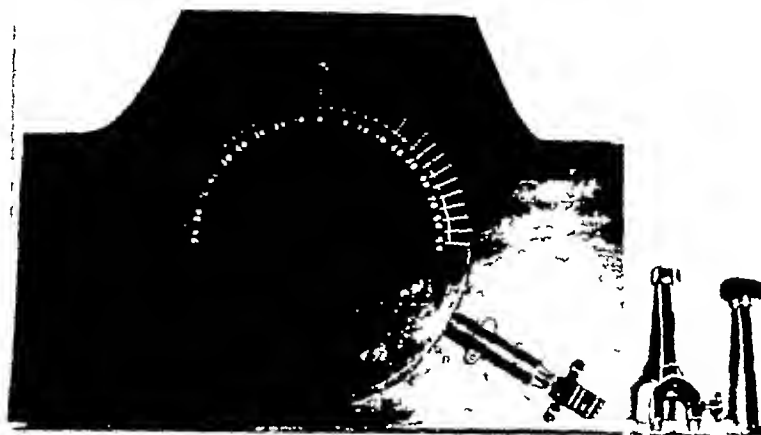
Platform for making oblique roentgenograms with upper surface graduated in degrees. The upper part is pivoted in the center and rotates on four ball bearings. A simple door stop brake device is located at the side.
